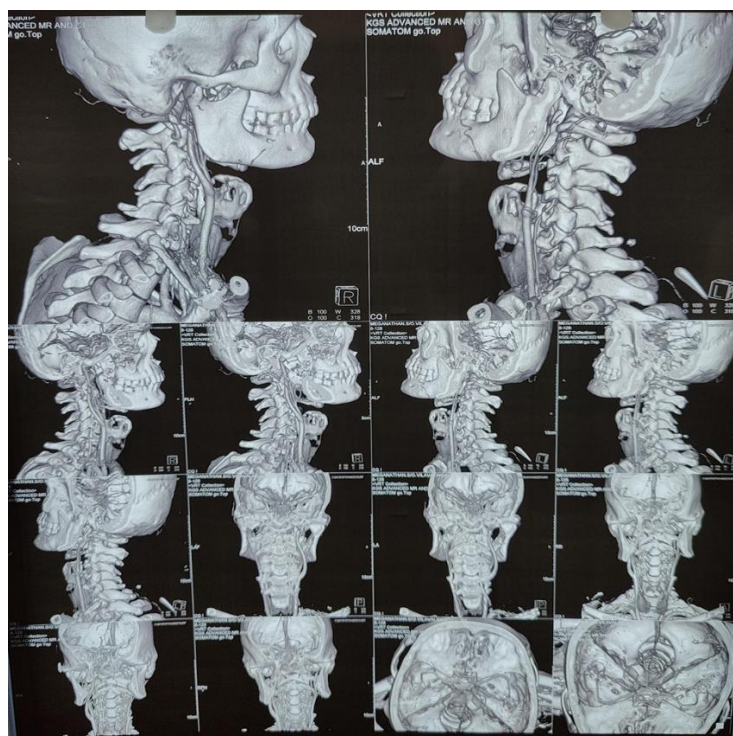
CT Angio Neck 3D Reconstruction
